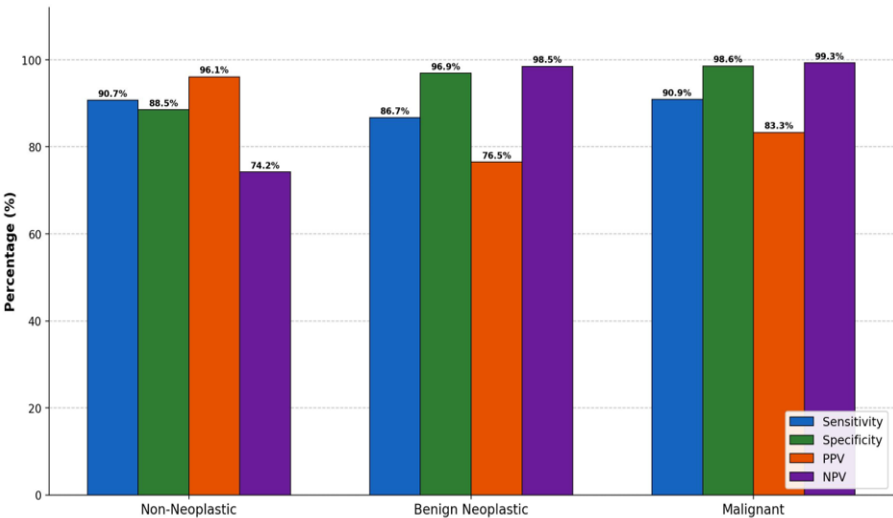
CT Diagnostic Performance for Sinonasal Mass Categories
